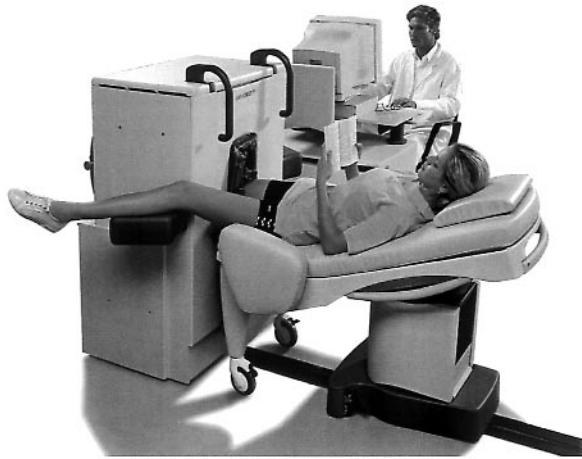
Small MRI systems. Low field strength closed (left: Artoscan, Esaote, Genoa, Italy) and open (MagneVu, San Diego, CA, USA) scanners are small, convenient, and inexpensive.
